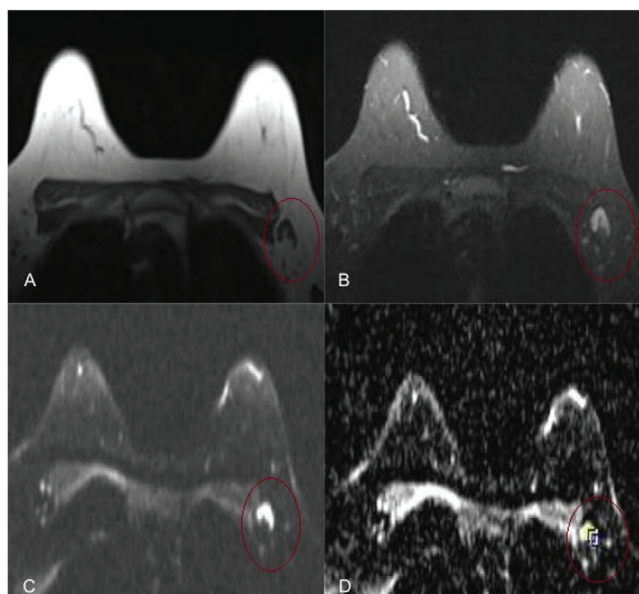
Forty-three year-old female patient diagnosed with tubular carcinoma of the left breast. There is a lymph node in the left axilla. A) T1-weighted and B) T2 weighted imaging) which is proven as reactive pathologically. No diffusion restriction is seen in C)DWI and D) ADC map
